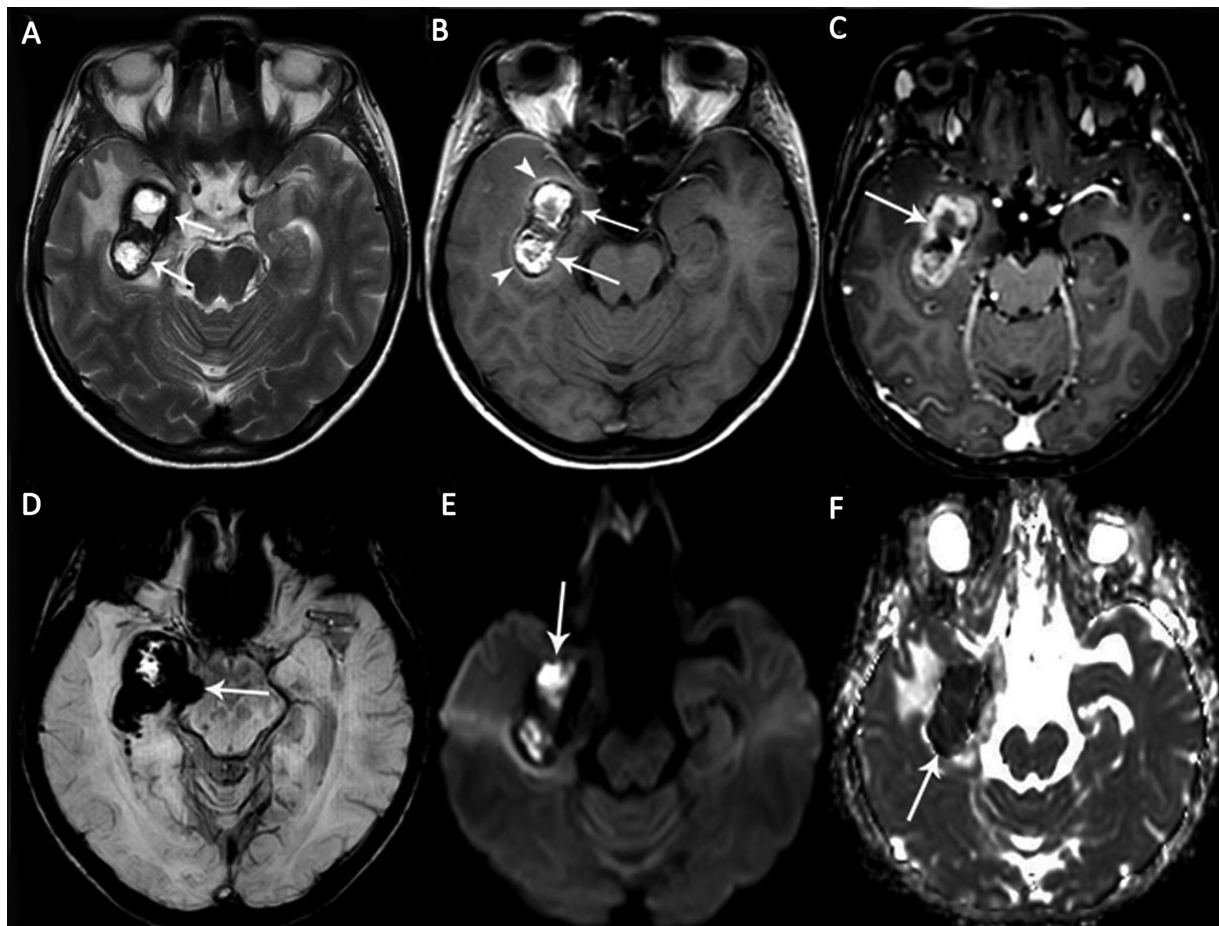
A right mesial temporal lobe cavernous malformation (CM) in a 42-year-old female patient with epilepsy. Axial (A) T2-weighted and (B) T1-weighted magnetic resonance (MR) images show hyperintense heterogeneous signals surrounded by a hypointense hemosiderin rim (*arrows*). There is the perilesional hyperintense sign on the axial T1-weighted MR image (*arrowheads*). (C) The mass shows intense peripheral enhancement on contrast-enhanced T1-weighted MR image (*arrow*). (D) There is a prominent inhomogeneous hypointense blooming artifact on susceptibility-weighted imaging (SWI) due to hemorrhage in the CM (*arrow*). The mass shows restricted diffusion as (E) hyperintense signals on diffusion-weighted imaging (DWI) and (F) hypointense signals on the corresponding apparent diffusion coefficient (ADC) map due to recent hemorrhage (*arrows*).
